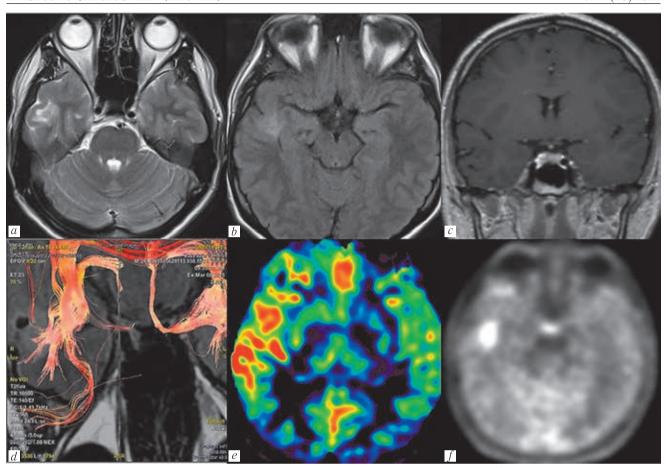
Мультимодальная предоперационная оценка, включающая рутинную MPT 1,5 Т и 3,0 Т по протоколу эпилептического сканирования, ПЭТ КТ. 1,5 Т МРТ выявила корково-подкорковый субстрат с признаками регионарного нарушения корковой организации, треугольной конфигурации, наличием мелких кист в структуре и трансмантийного признака хорошо видного в режиме FLAIR. Отсутствие перифокальной реакции, масс-эффекта или контрастного усиления, трансформацию размеров и конфигурации в течение восьми лет (a, b, c). 3,0 Т МРТ на трактографии (DTI) показала деформацию проводящих путей без признаков инфильтрации или нарушения целостности (d). Бесконтрастная MP — перфузия (ASL) продемонстрировала локальную и региональную гиперперфузию (e). ПЭТ КТ показала накопление радиофармпрепарата (¹¹С-метионин) в структуре патологического субстрата (f) Fig. 2. Multimodal pre-surgical evaluation including 1.5 T and 3.0 T MRI using epilepsy protocol, PET CT.1.5 TMRI showed a cortical-subcortical substrate with signs of regional disturbance of the cortical organization, triangular configuration, small cysts in the structure, and a transmantle sign in the FLAIR mode. No perifocal reaction, mass effect or contrast enhancement; transformation in size and configuration were observed for eight years (a, b, c). 3.0 T MRI DTI showed deformation of neuronal pathways without signs of infiltration or integrity loss (d). ASL demonstrated local and regional hyperperfusion (e). PET CT showed accumulation of radiopharmaceutical drug (¹¹C-methionine) in the structure of the pathological substrate (f)
